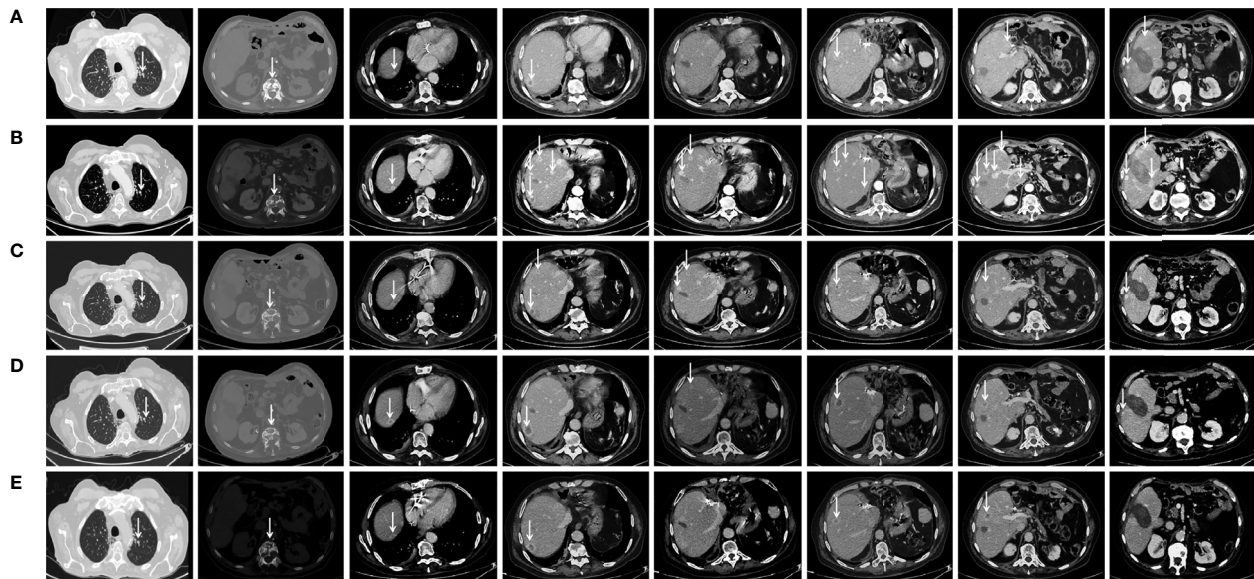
Chest CT-scan performed at diagnosis in February 2019 at tumor progression following chemotherapy with cisplatin and gemcitabine and a third percutaneous thermal ablation and before to start treatment with FOLFIRI (A), in June 2019 at tumor progression following six cycles of FOLFIRI administration and before to start treatment with olaparib (B), in September 2019 following three cycles of olaparib (C), in November 2019 following six cycles of olaparib (D), and in February 2020 following 11 cycles of olaparib (E). Arrows indicate tumor lesion.
